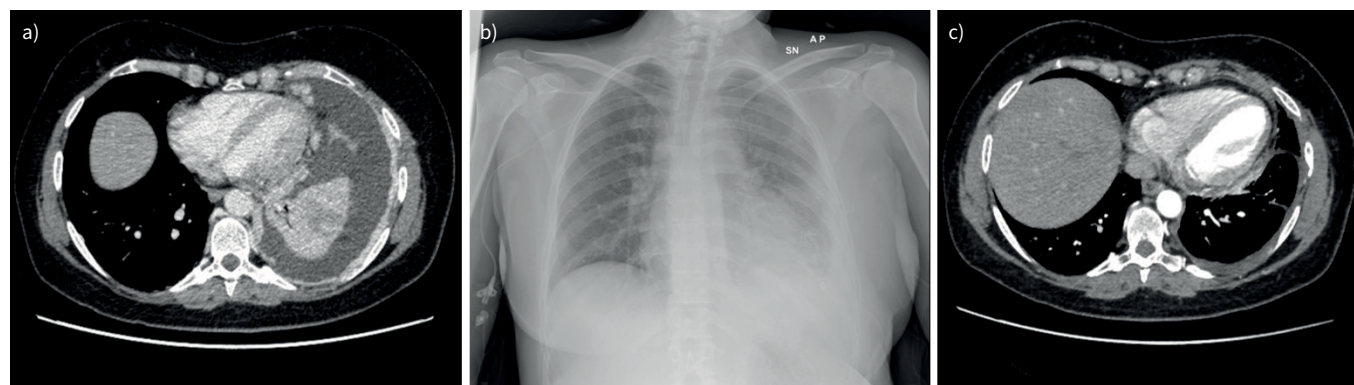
Patient with recurrent malignant pleural effusion secondary to breast cancer, already subjected to talc slurry, with consequent recurrence of symptomatic effusion successfully treated with an indwelling pleural catheter. a) Left pleural effusion with pleural thickening. b) Chest radiograph immediately following placement of an indwelling pleural catheter. c) Achievement of complete pleurodesis after catheter placement and modification of molecular targeted oncological therapy.
